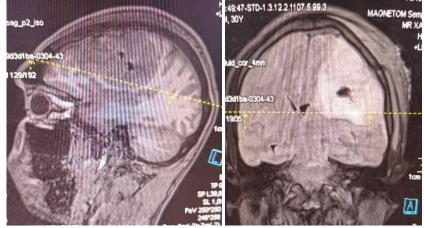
MRI in T1, T2 and T2 Flair sequence, in axial, coronal and sagittal section showing the MRI appearance of the meningioma which appears as a slightly hypointense extra-axial mass in T1 weighting, strongly hyperintense in T2
